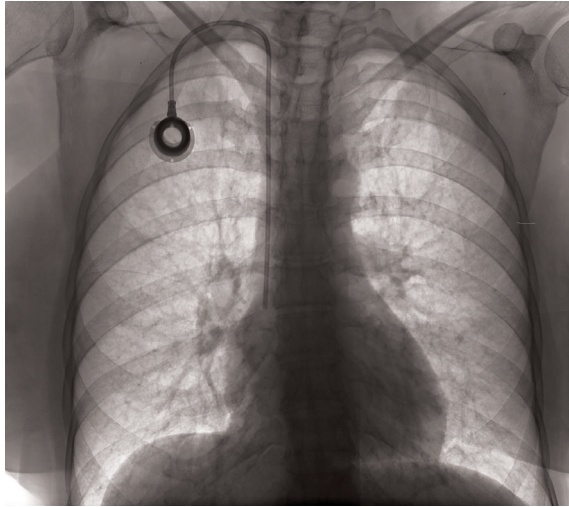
Digital radiography of the subject who underwent placement of port catheter through right internal jugular vein.
